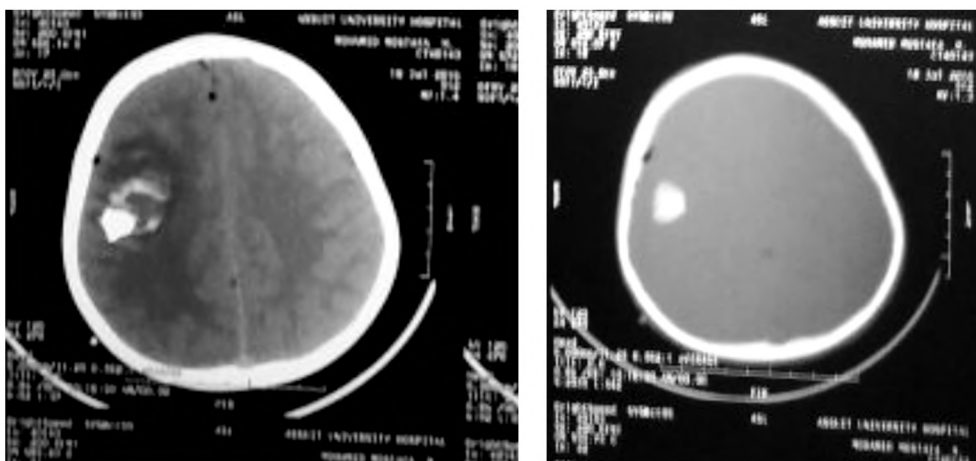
CT soft tissue window shows complete removal of the wooden object with residual unaccessible bone fragment.
